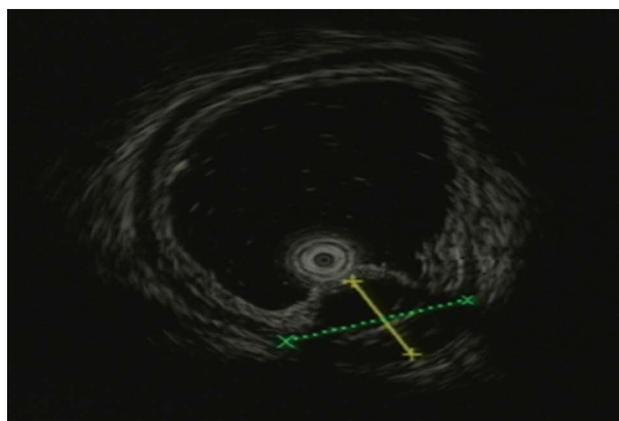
Endoscopic ultrasonography. An anechoic mass with an irregularly thickened wall was observed in the submucosal lining of the stomach.
